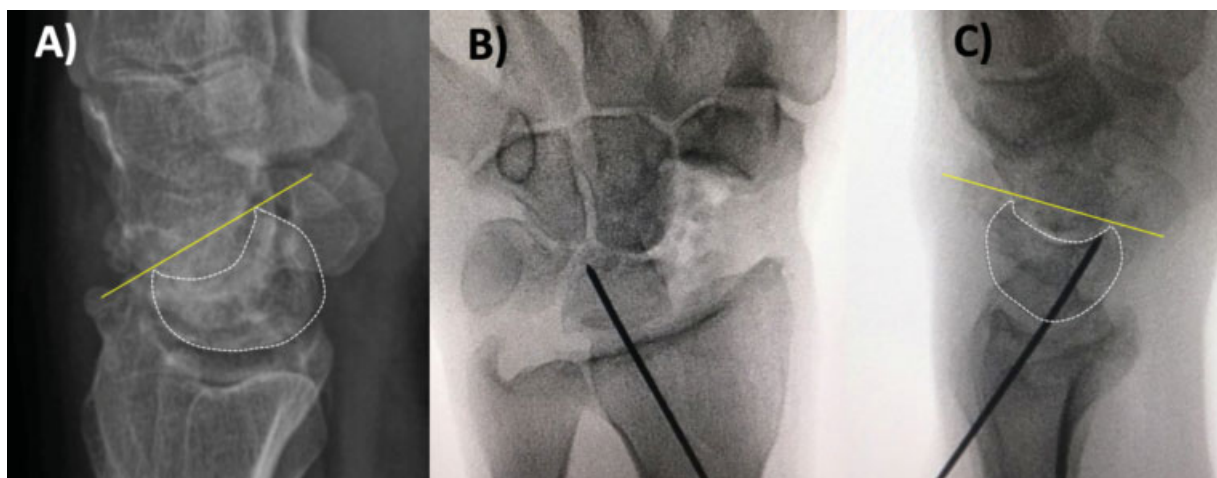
Reduction of dorsal intercalated segment instability (DISI) through lunate reduction. (A) Preoperative lateral wrist radiograph of a patient with DISI. (B,C) Intraoperative anteroposterior and lateral radioscography, respectively, of lunate reduction with a radiolunate Kirschner wire.
